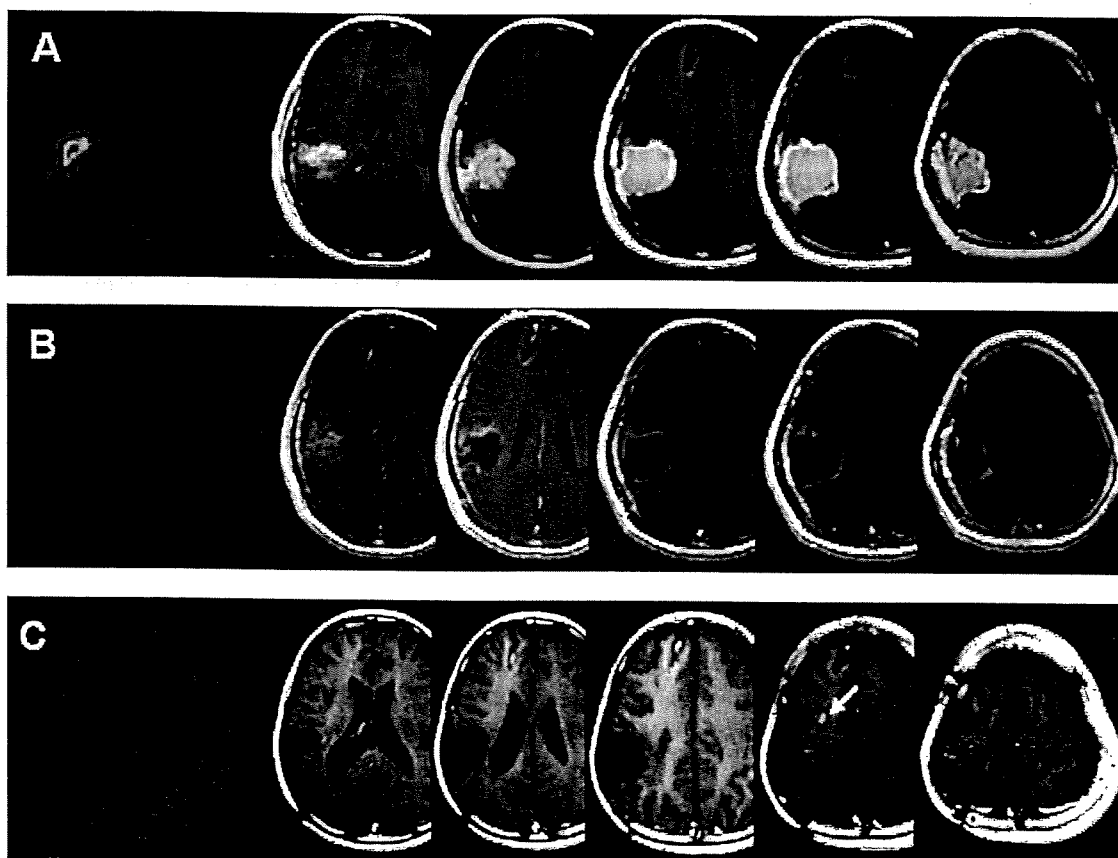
Case 17: An 18-year-old female had a right parietal glioblastoma partially removed in a hospital in May 2005 (A). We performed re-craniotomy to remove the additional tumor and settled the Ommaya's reservoir to fill the cavity with air before neutron irradiation (B). MRI taken 26 months after BNCT is shown in C. The white arrow shows a newly appearing Gd-enhanced lesion, which was judged to be radiation necrosis. BPA-PETs taken prior to BNCT and 2 years after BNCT are listed in the left panel in rows A and C, respectively.
